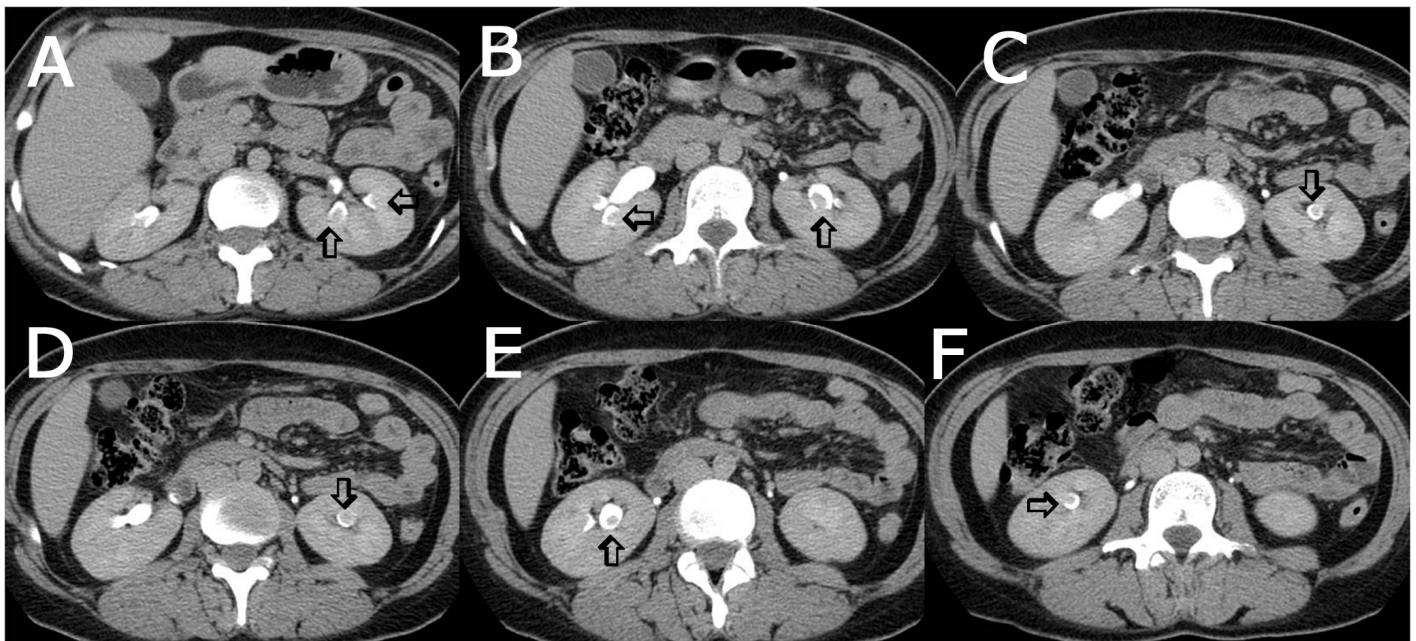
Axial, sequential, cross-sectional computed tomography with intravenous contrast enhancement in late-phase images showing multiple, bilateral, round-shaped, mass-like lesions protruding the renal collecting system (blank arrows). These lesions in late-phase images show the same enhancement pattern as the renal cortex and medulla, supporting hypertrophied columns of Bertin.
